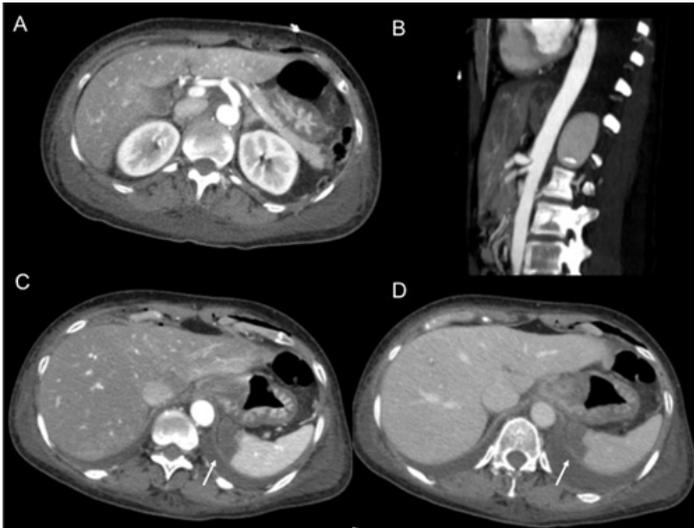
Contrast-enhanced CT angiography, at emergency department. Axial view (A) and sagittal reconstruction (B) of the upper abdomen showing the characteristic hook appearance on the proximal celiac axis when it is compressed by the MAL (in sagittal view). Axial views at an upper level, in the arterial phase (C) and in the portal phase (D) showing heterogeneous opacification of the liver parenchyma in the arterial phase that becomes homogeneous in the portal phase, suggesting perfusion abnormalities in the liver parenchyma. Also, hyperenhancing gastric mucosa and an hypoattenuating area at the periphery of the spleen (arrow), suggesting ischaemic alterations.
